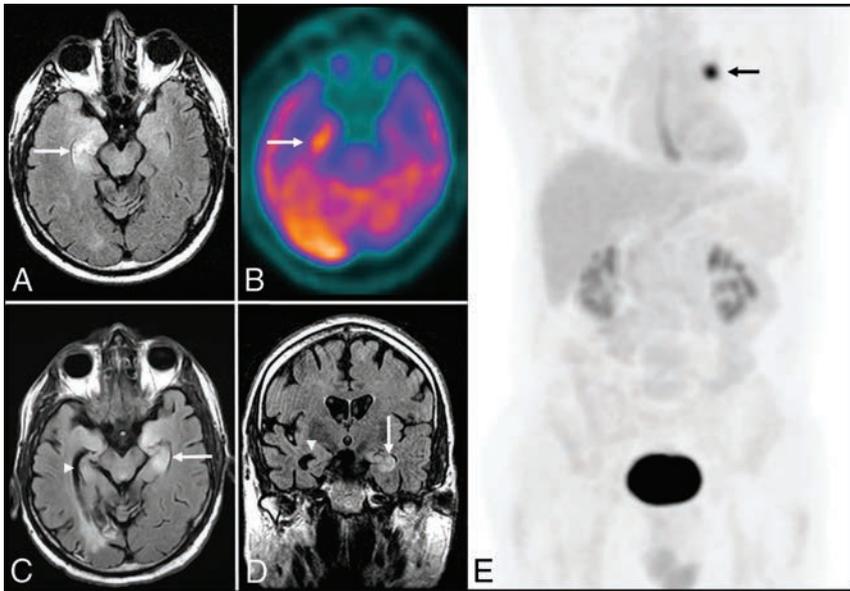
Anti-Hu encephalitis. A 68-year-old man with chronic obstructive pulmonary disease presented with gradually worsening memory deficits and confusion, with subclinical seizures. MR imaging of the brain demonstrates T2-FLAIR hyperintensity and mild expansion in the right medial temporal lobe (A), right insular cortex (not shown), and left dorsal thalamus (not shown), without restricted diffusion (not shown) or postcontrast enhancement (not shown). FDG-PET of the brain demonstrates a hypermetabolic focus within the right medial temporal lobe lesion (B). PET of the body demonstrates a hypermetabolic focus in the left lung (E), consistent with biopsy-proved small-cell lung cancer. The patient was in remission following treatment with intravenous immunoglobulin infusions, oral steroids, and chemotherapy, but he presented approximately 2.5 years later with worsening memory decline. MR imaging at that time (C and D) shows new T2-FLAIR hyperintensity in the left medial temporal lobe (white arrow) with volume loss within the right medial temporal lobe (white arrowhead). An old right occipital lobe infarct is also incidentally noted.
